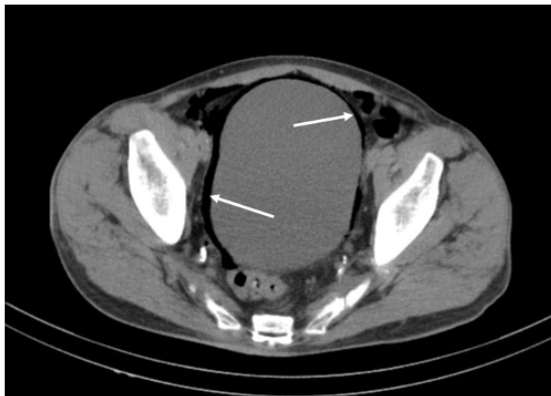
The axial imaging from the initial CT scan of the abdomen and pelvis revealing emphysematous changes within the bladder wall.
